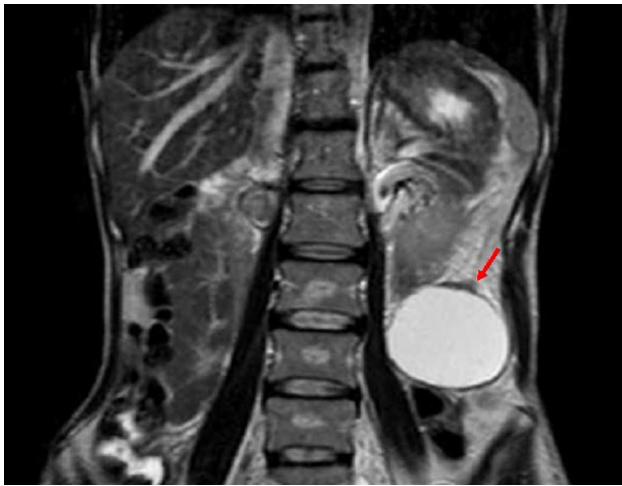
Coronary T2-weighted MRI findings of retroperitoneal serous adenocarcinoma. The cystic mass was extending into the retroperitoneum and adjacent to the lower pole of the left kidney
